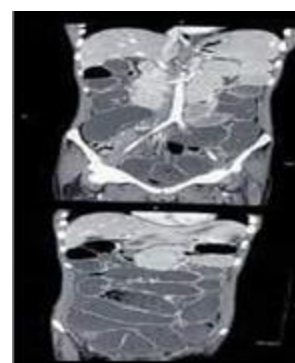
Axial view CT scan showing multiple dilated small bowel loops with specks of air within it.
